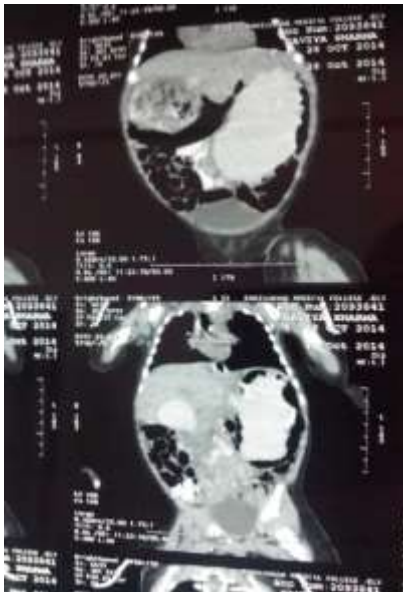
Contrast CT showing dilated stomach and duodenum.
